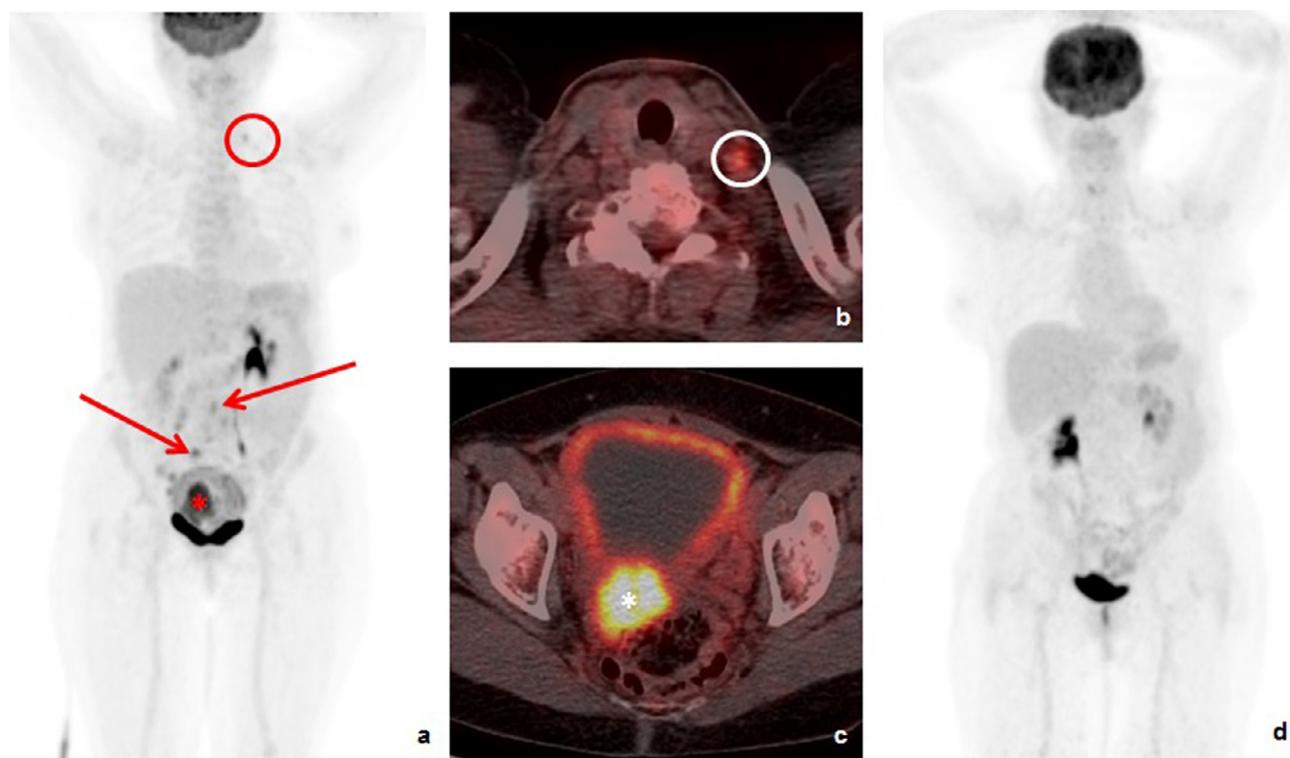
Cervical cancer staging: 64 year old with FIGO stage IIIb cervical carcinoma. Staging FDG PET/CT imaging (a-c) demonstrates the intensely avid primary cervical tumour (*) with a fluid-filled endometrial cavity and right hydronephrosis. There are moderately FDG avid small volume pelvic and para-aortic nodes (arrows) with a suspicious left supraclavicular node (circle) – stage IV disease. The para-aortic and supraclavicular nodal disease was not identified on CT or MRI. Biopsy of the supraclavicular node confirmed metastasis. The PET/CT changed the management plan and the patient was treated with chemoradiotherapy to include the aortic strip + brachytherapy. The repeat FDG-PET/CT 3 months after treatment (d) demonstrates complete metabolic response. The patient remains disease free 2 years following treatment.
